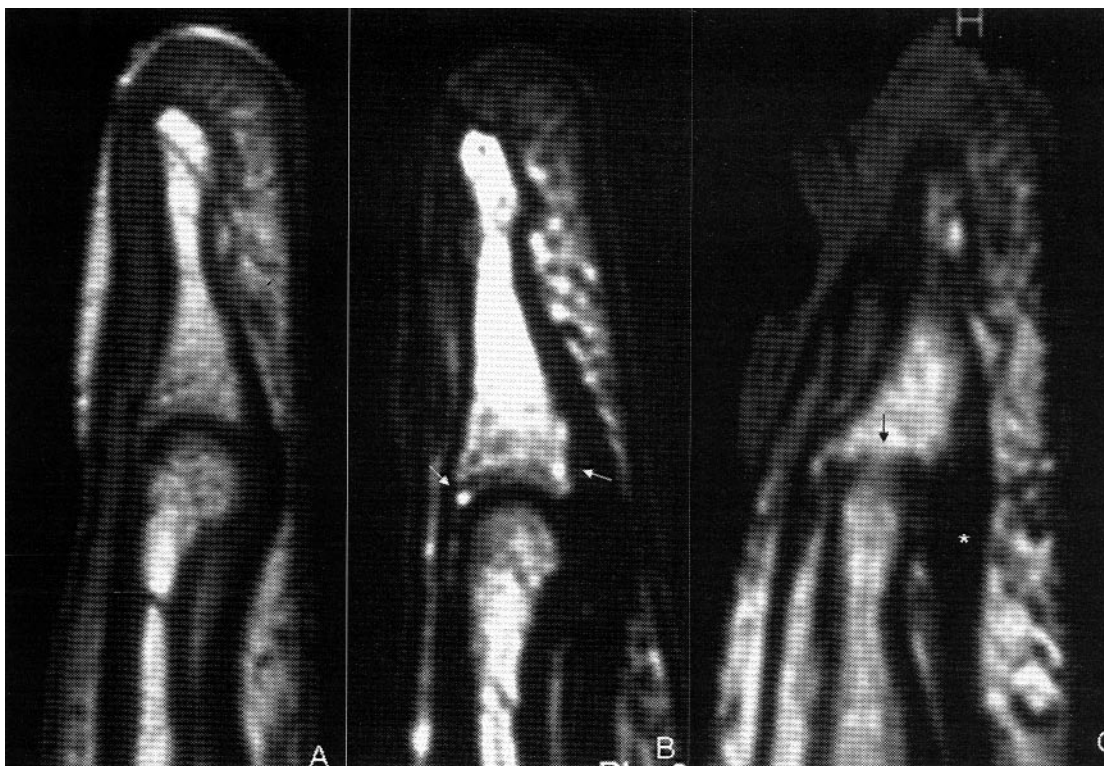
MRI of the distal phalanx: TSE T1 sagittal (A) and TSE T2 sagittal (B and C) images. A. Normal DIP joint in a control subject. B. Patient with PsA without onychopathy. There are focal abnormalities of bone signaling at the base of the DP (arrow) due to arthritis (grade 1). C. Patient with PsA and onychopathy. An advanced structural modification of the DIP joint is shown, with morphological alteration of the articular surfaces and narrowing of the joint space (arrow; grade 2). Enthesopathy of the flexor tendon is also detectable (asterisk).
